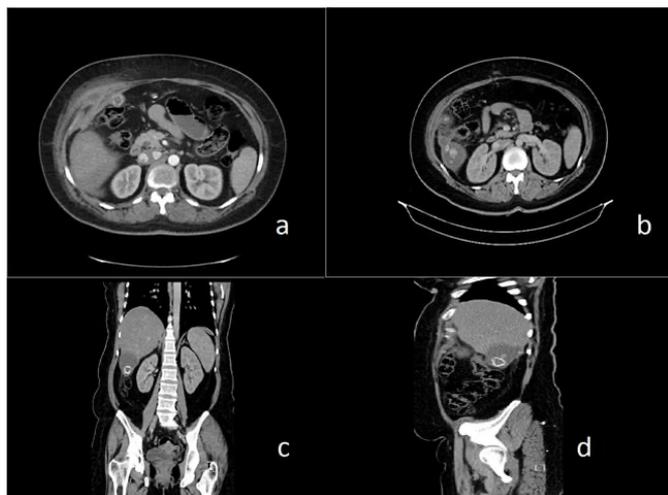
Computed tomography images of abscess on the abdominal wall in transverse (1a), subhepatic abscess in transverse (1b), coronal (1c) and sagittal (1d) planes
